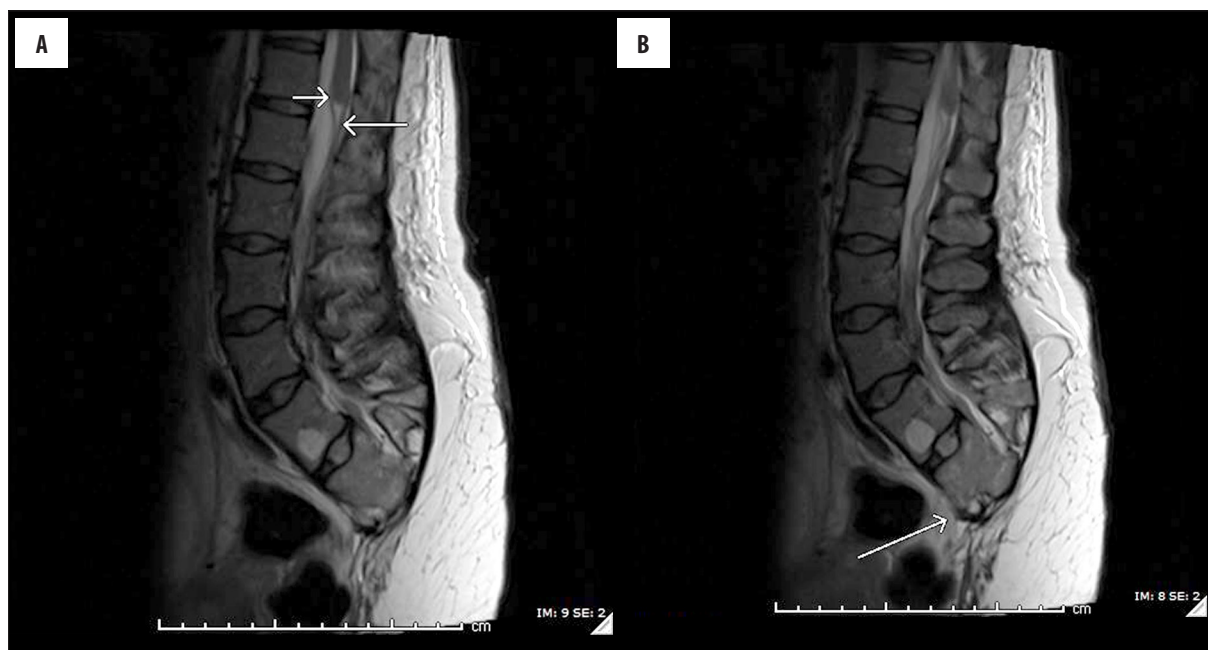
(A) Sagittal T2-weighted MR image in a 30-year-old woman shows a high and abrupt termination of the spinal cord with a blunt-ending conus medullaris (smaller arrow), and double-bundle arrangement of the nerve roots (larger arrow). (B) Sagittal T2-weighted MR image in a 30-year-old woman shows absent S3–5 and coccygeal segments with dysplastic S1 and S2 (arrow).
